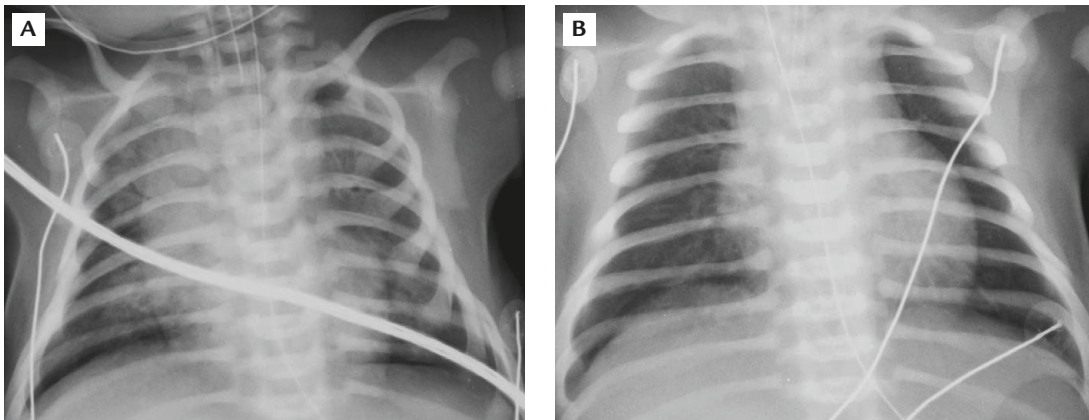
Chest X-ray of Case 3: (A) before lavage; (B) 24 hours after lavage.
